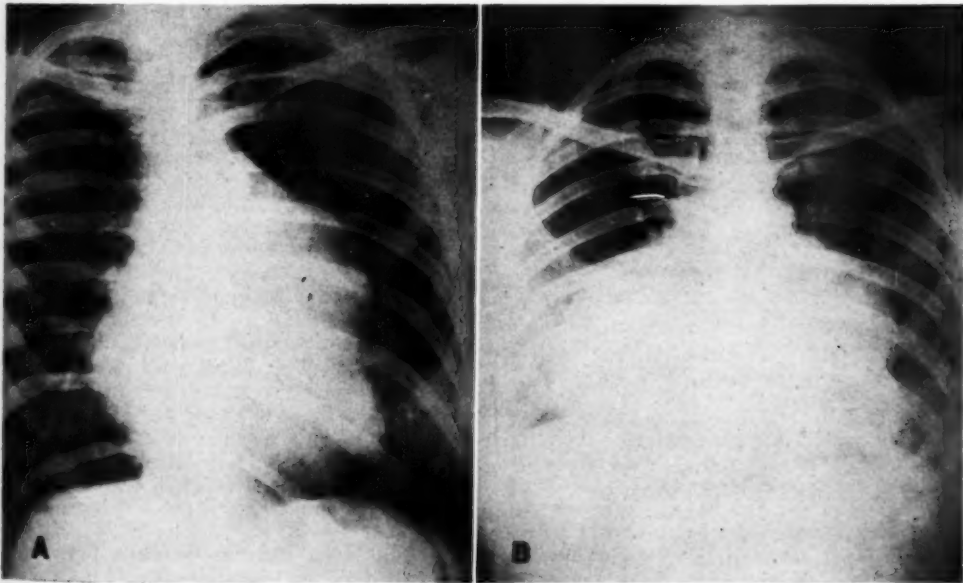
Roentgenograms taken April 14, 1942, in inspiration (A) and expiration (B).
